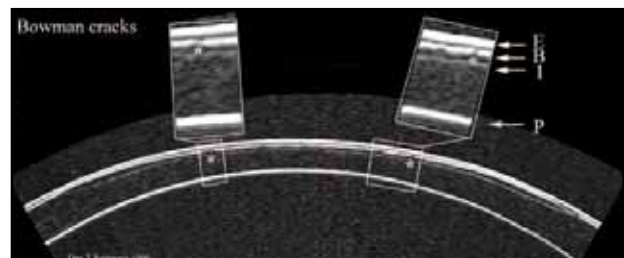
Bowman's cracks. Horizontal VHF digital ultrasound corneal B-scan through the visual axis of a patient 9 months after LASIK. The surface of epithelium (E), Bowman's layer (B), the keratectomy interface (K), and the endothelium (P) are labeled. Inspection of the Bowman's interface demonstrates fractures or discontinuities (*) that do not involve grooving or puckering of Bowman's layer.
